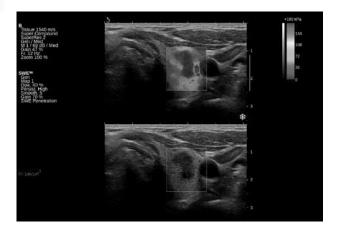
Sonoelastographic (upper part) and ultrasonographic (lower part) picture of lesion in left thyroid lobe
